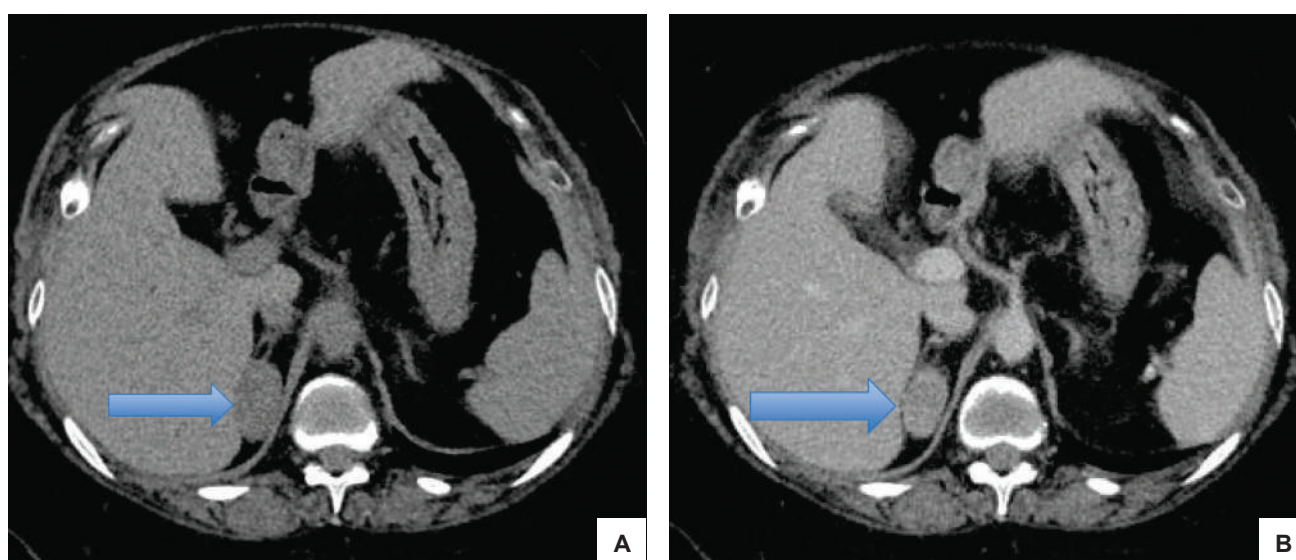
(A) CT adrenal pre-contrast scan showing the right adrenal adenoma (blue arrow); (B) CT adrenal post-contrast scan showing the well-defined hypodense lesion at the medial limb of the right adrenal gland.
